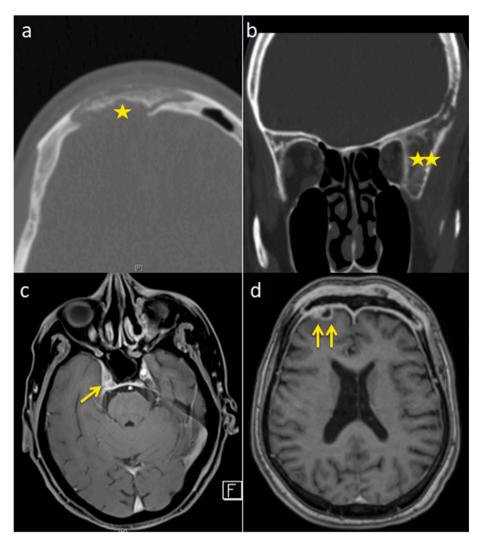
Pre-operative imaging: (a) Plain axial CT of a 32-year-old female showing osteomyelitis of the right side of the frontal bone and sequestrum formation (single star) with PPT. (b) Plain coronal CT of a 67-year-old male showing osteomyelitis of the left frontal bone adjacent to the frontal sinus (double star) without PPT. (c) Axial gadolinium enhanced T1-weighted MRI in a 65-year-old male showing fungal disease in the right cavernous sinus chronic partial thrombosis (single arrow). (d) Axial gadolinium enhanced T1-weighted MRI in a 61-year-old female showing thickening and enhancement of the bilateral frontal dural with a small underlying right frontal abscess (double arrow).
